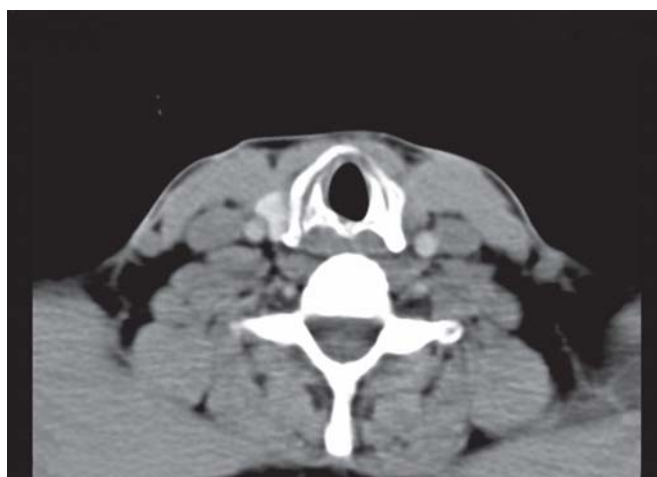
CT neck transverse view 2 months after surgery showing significant dilatation of glottic and subglottic airway (plain, slice thickness: 1 mm)
